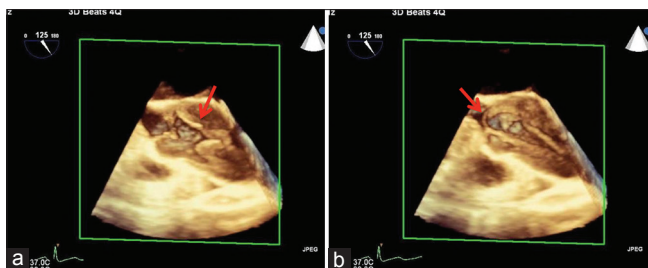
(a) Three-dimensional transesophageal echocardiography (3D TEE) showing dissection flap (red arrow) in ascending aorta during systole. (b) 3D TEE showing dissection flap (red arrow) prolapsing into aortic valve during diastole causing severe aortic regurgitation
